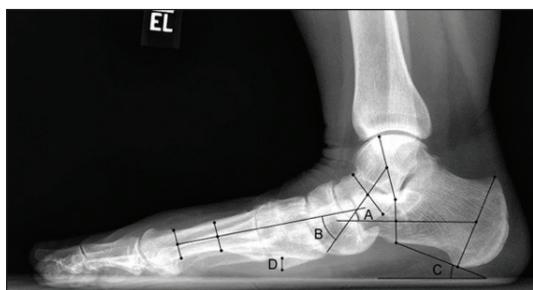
Lateral radiograph pes plano valgus
